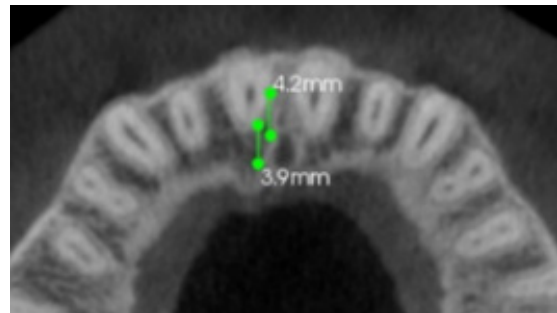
Antero-posterior measurements in axial section of CBCT
